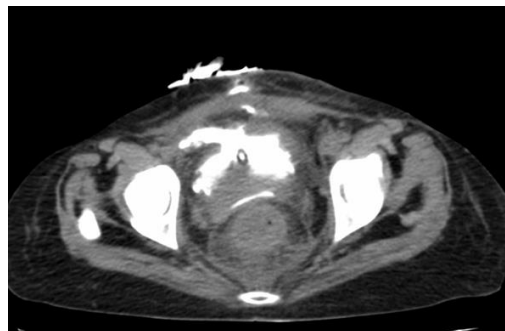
Axial CT images in the same patient shows a defect in the anterior wall of urinary bladder through which contrast is possibly extravasating.
